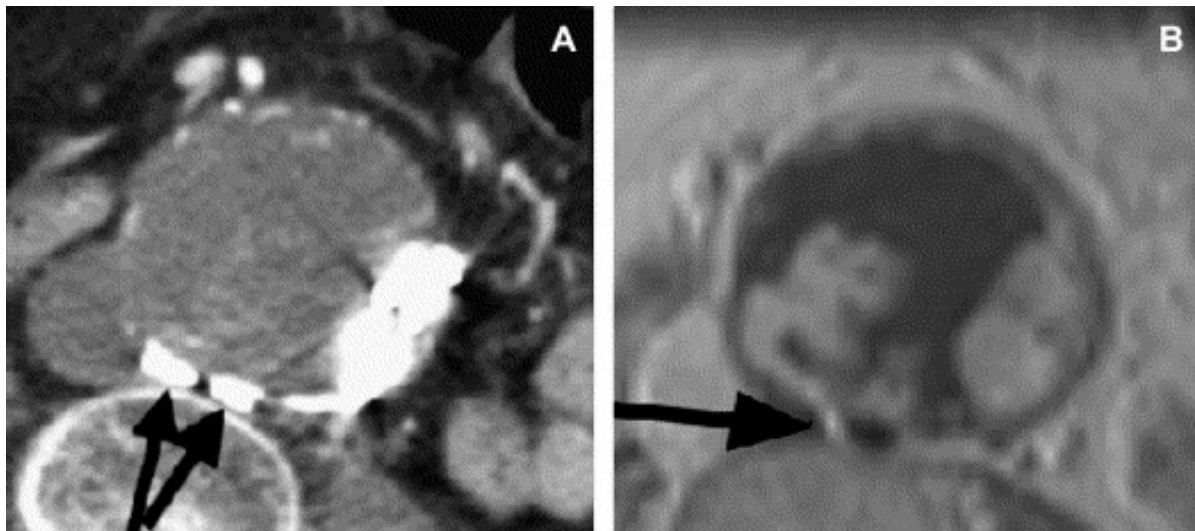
Magnetic resonance images of a type II endoleak. (A) Computed tomography (CT) of an abdominal aortic aneurysm status post endovascular aneurysm repair (EVAR) and surgical clipping of paired lumbar arteries (arrows). As per the authors, the endoleak was occult. (B) T1 post-contrast axial image of the corresponding aneurysm demonstrates hyperintense contrast extending from the region of the clips (arrow) into the aneurysm sac, suggestive of a type II endoleak. Adapted from (108).
